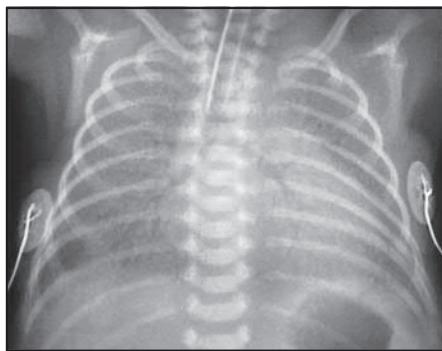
Chest X-ray in respiratory distress syndrome showing a diffuse granular or 'ground glass' appearance of the lungs and an air bronchogram, where the larger airways are outlined. The heart border is indistinct. A tracheal tube is present. (From: Lissauer T, Fanaroff AA, Moll L, et al: *Neonatology at a Glance*, ed 3. Oxford, 2015, Wiley Blackwell, with permission.)
